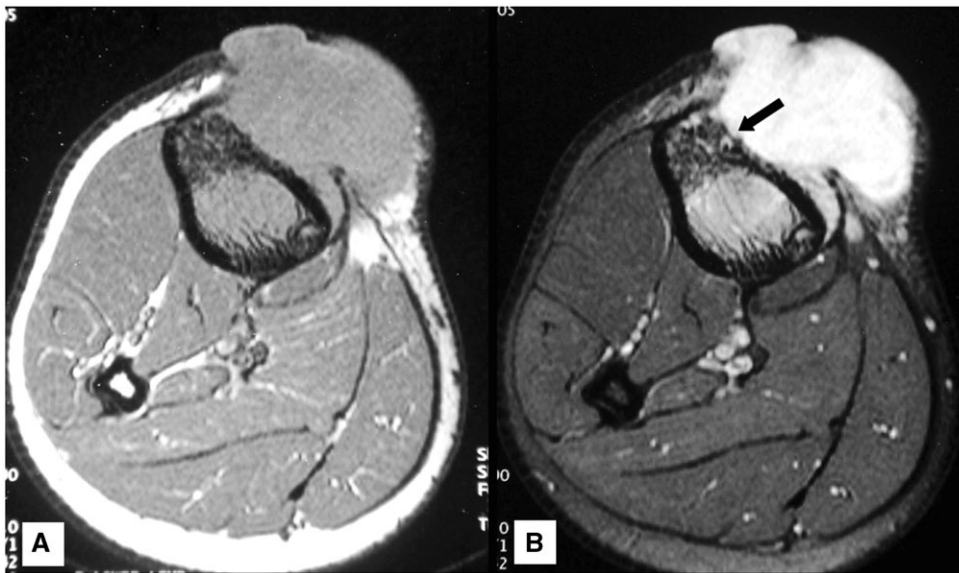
MRI axial T1-weighted pre-contrast (A) and post-contrast (B) images depicting large soft tissue bulging anteromedial to the right tibia and showing florid enhancement after contrast administration. Mild heterogeneous enhancement is also noted in the underlying bone marrow. The soft tissue is seen to infiltrate the subcutaneous planes associated with cortical breach in the tibia anteriorly (arrow, B).
